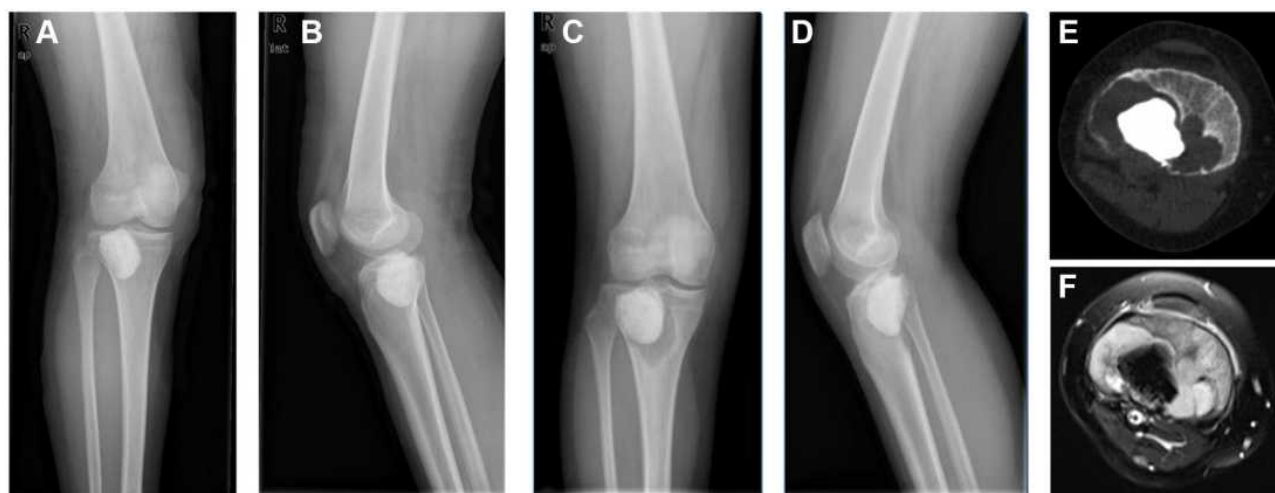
Radiological images of the proximal right tibia. Radiograph (A and B), postoperative films following the curettage and packing with cement; Radiograph (C and D), and CT (E, bone window) showed a circumferential lucency around the bone cement and local cortical bone destruction. MRI (F, T1-weight) showed a soft tissue mass.
